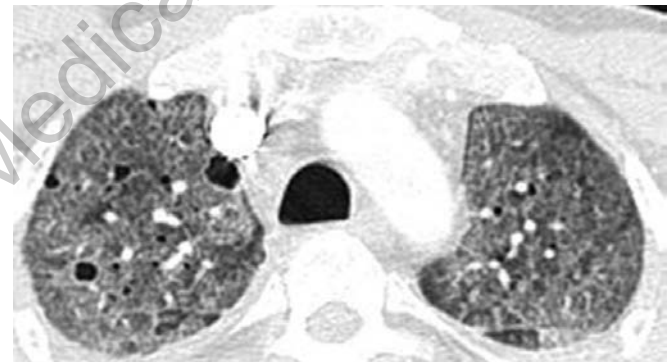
A classic CT chest representation of diffuse ground glass attenuation in a patient with *Pneumocystis carinii* pneumonia
